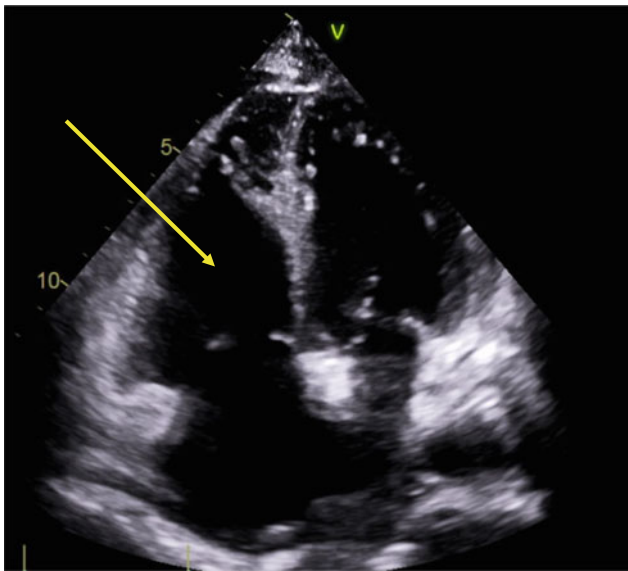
Transthoracic echocardiogram: moderate RV dilation (arrow)
